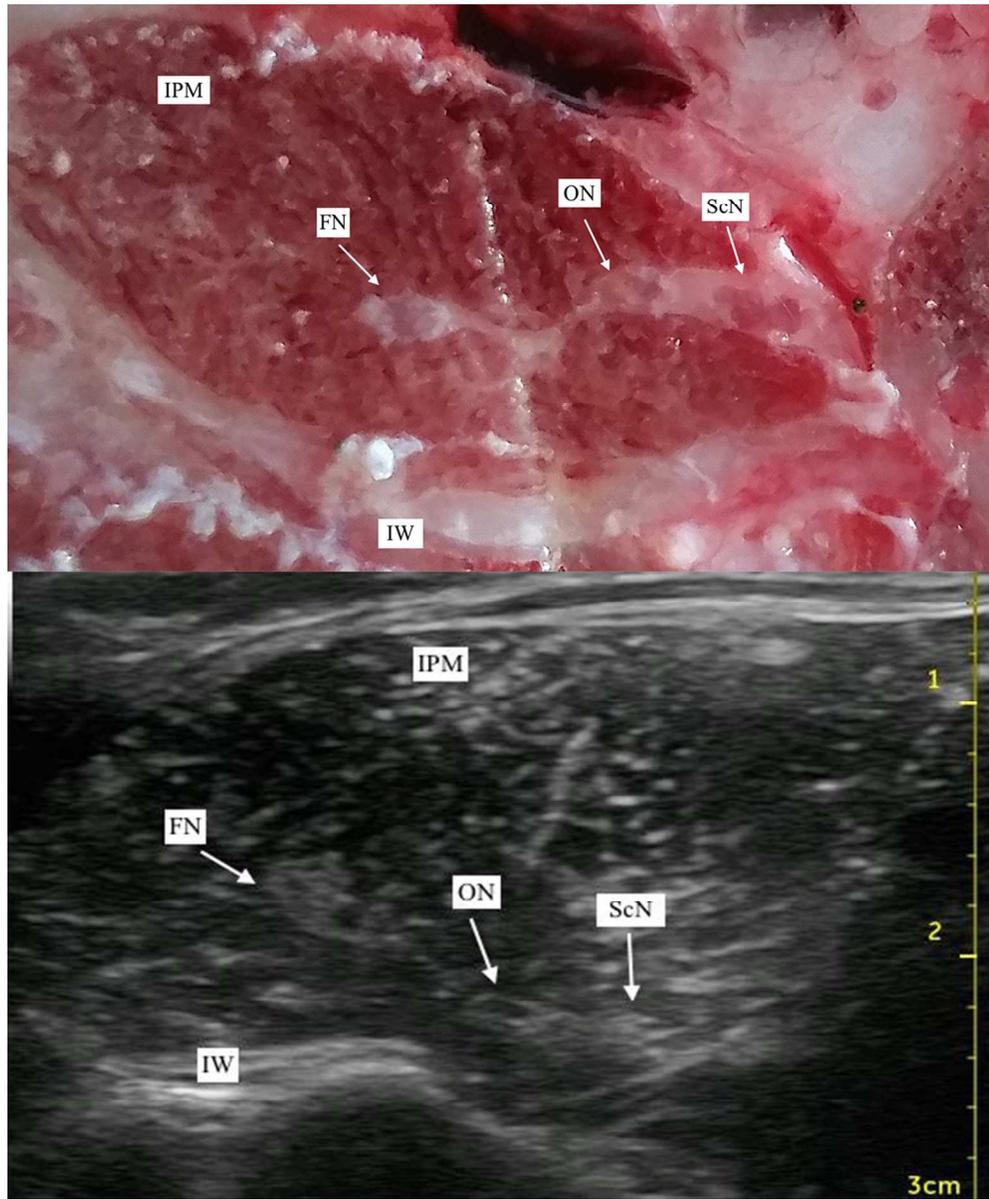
Cryosection and ultrasound images of the iliopsoas muscle (IMP) caudally to the target point. The femoral nerve (FN) is visible in the left side of the picture, the obturator nerve (ON) is between the FN and the sciatic nerve (ScN).
